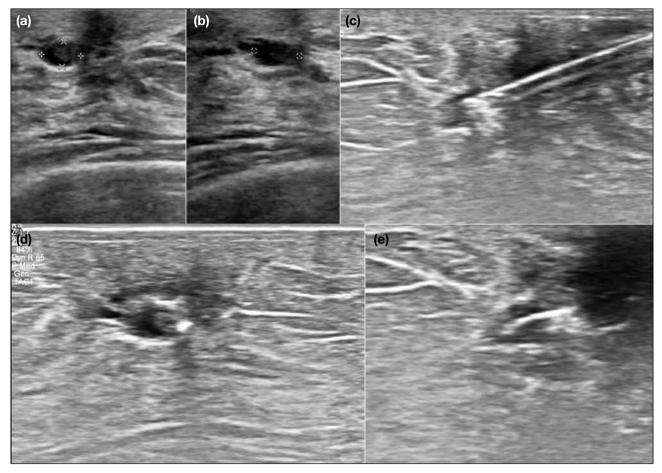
Case 2. A 55-year-old woman with a history of lumpectomy for right breast papilloma. (a) Transverse and (b) longitudinal ultrasound images showing an intraductal lesion measuring $5 \times 3 \times 5$ mm at right breast 5 o'clock position at the subareolar region. (c) Ultrasound image showing needle within the lesion under ultrasound guidance deploying the Magseed. (d) Transverse and (e) longitudinal ultrasound images showing of Magseed in situ.
